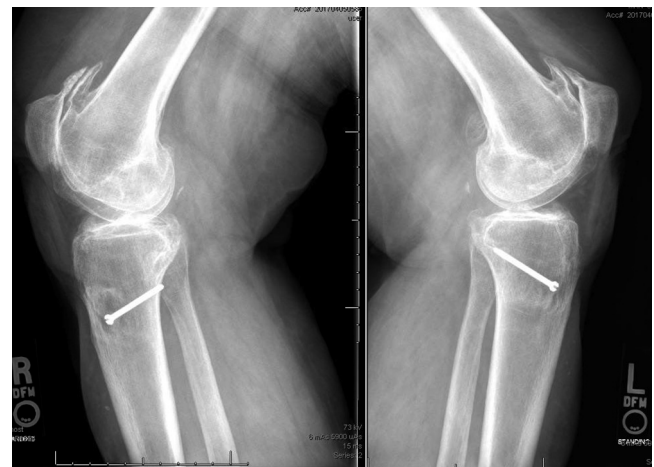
Case 2: Preoperative lateral radiographs noting the medialization of the screw head past the expected point of the tubercle.
